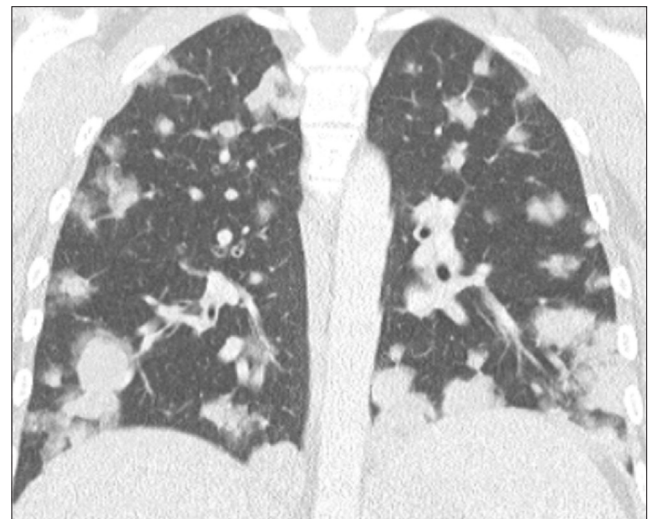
Chest computed tomography scan evidencing pulmonary metastases 3 weeks after delivery.
